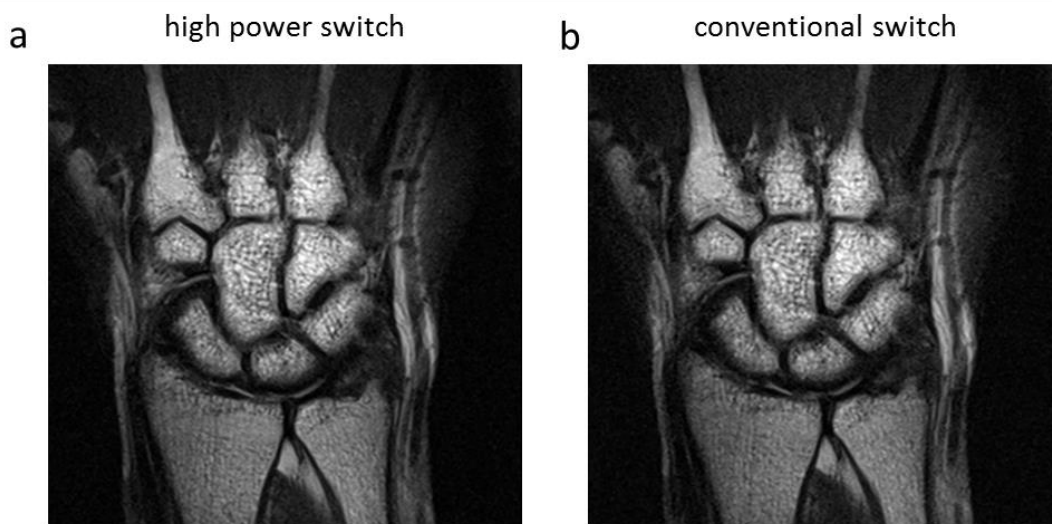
Wrist MRI performed with a) high power Tx/Rx switch and b) conventional switch. Image adapted from [1].
